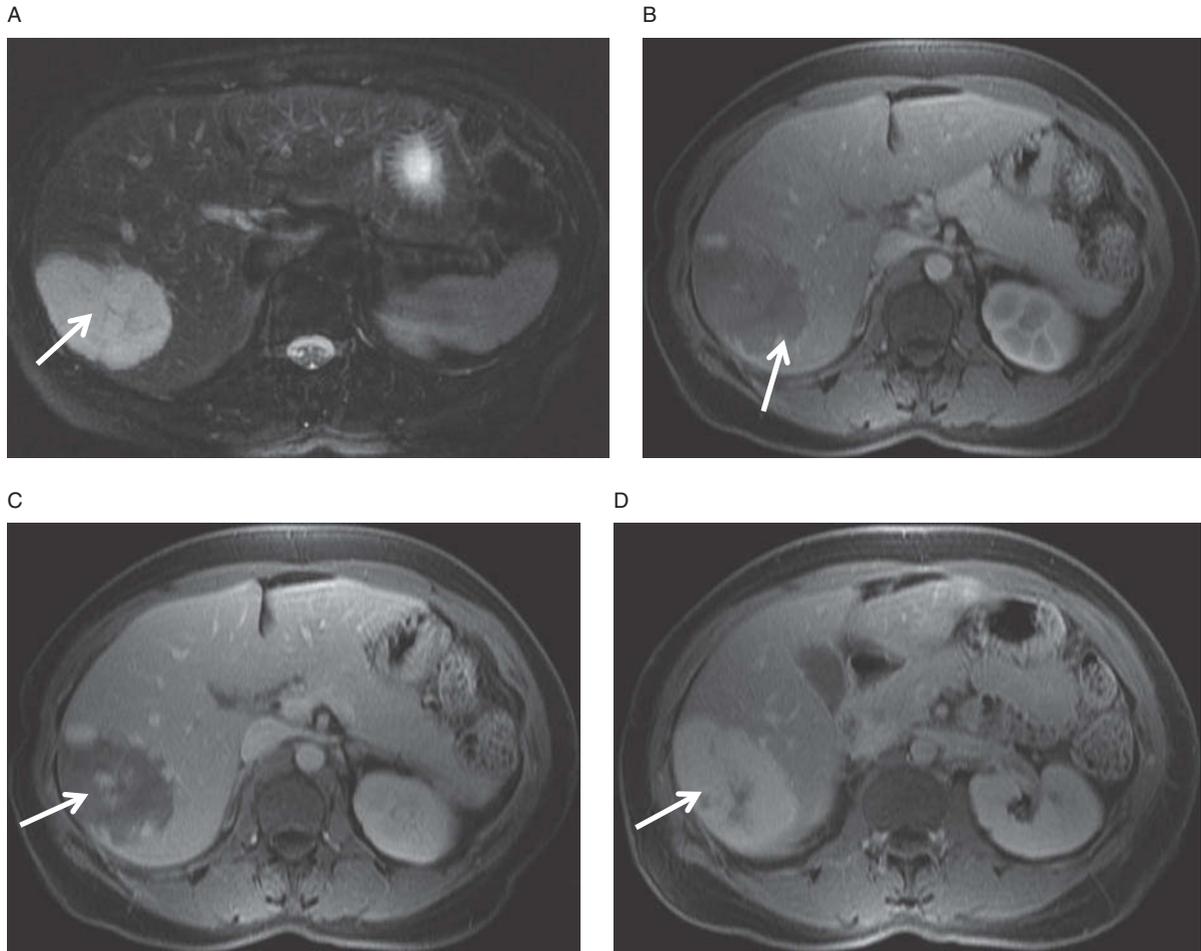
Classic hemangioma. Axial, fat-suppressed T2-weighted image (A) shows markedly bright, lobulated liver lesion. Axial, T1-weighted fat-saturated post-contrast enhanced images obtained in the arterial phase (B), portal venous phase (C), and delayed phase (D) demonstrate peripheral, nodular, discontinuous enhancement with progressive fill-in of contrast over time. (See arrows).
